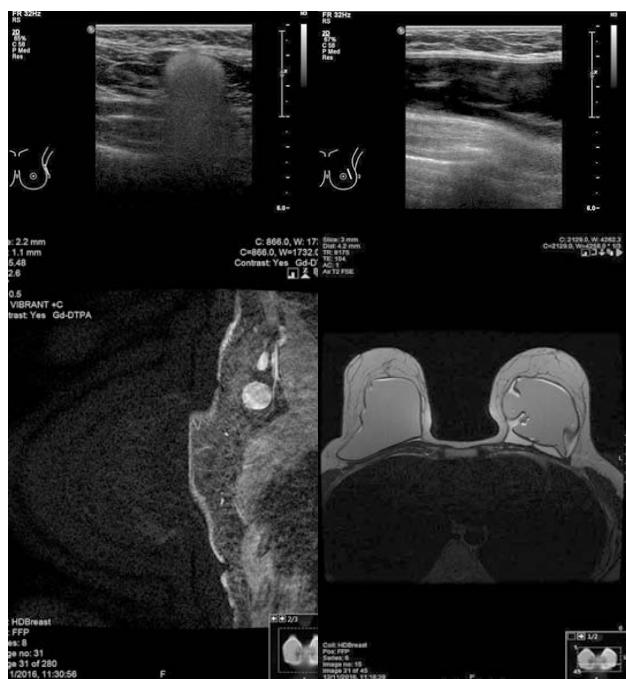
Ultrasound breast demonstrating snow storm appearance of axillary lymph node representing silicone infiltration due to extracapsular rupture. Multiple intraluminal membranes represent intracapsular rupture. MRI confirms both extracapsular and intracapsular rupture of silicone implants. Ultrasound Images demonstrate how the snow storm appearance makes ultrasound highly sensitive for the diagnosis of extracapsular rupture.
